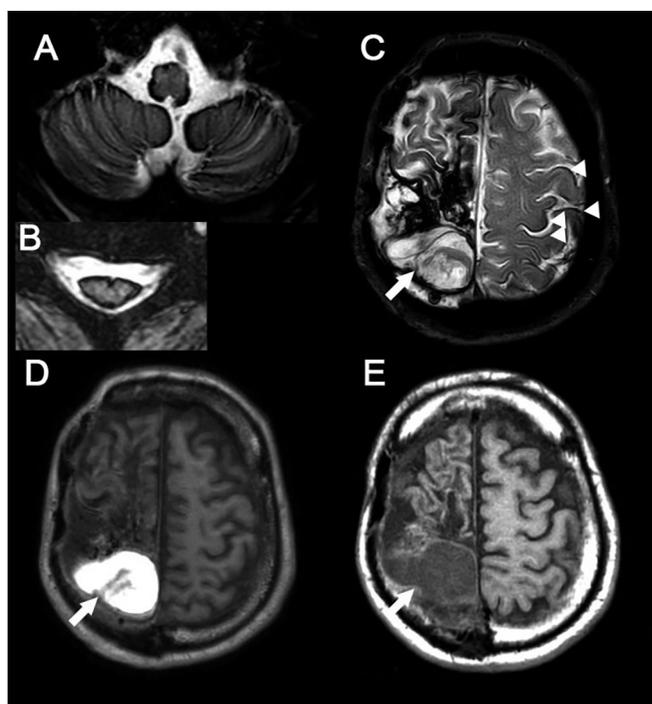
Magnetic resonance imaging (MRI) findings for a male patient with superficial siderosis of the central nervous system that occurred as a late complication of neurosurgical procedures for cerebral arteriovenous malformation. (A, B, and C) Axial T2-weighted brain MRI shows hypointensity on the surface of the cerebellum, pons (A), and spinal cord (B) because of hemosiderin deposition. There is extensive hemosiderin deposition in the right hemisphere (C). Dense hemosiderin deposits outlining several gyri in the left hemisphere are represented by areas of marked hypointensity (arrowheads). A postoperative cystic lesion is also present in the right posterior lobe (arrow). (D) Axial T1-weighted brain MRI shows hyperintensity in the cystic lesion (arrow). (E) Axial T1-weighted brain MRI performed 8 months prior at another hospital shows isointensity in the cystic lesion (arrow). The signal changes between (D) and (E) suggest recent bleeding.
